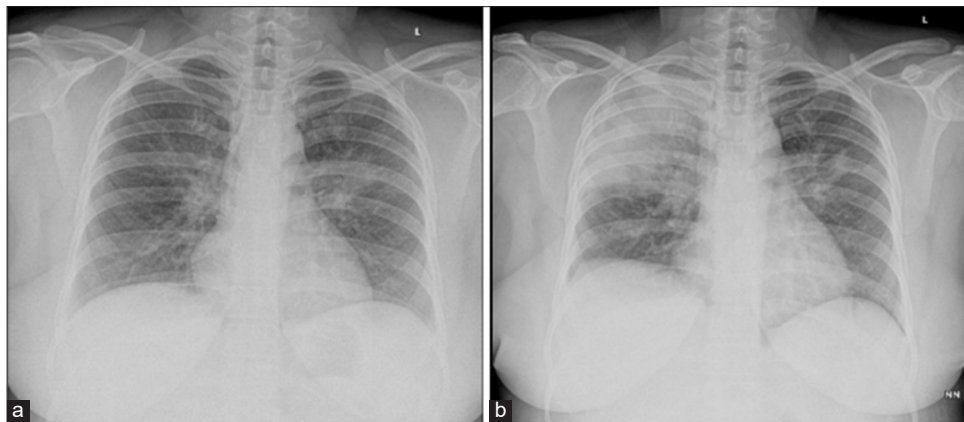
Normal chest radiograph (postero-anterior view) (a). Chest radiograph (postero-anterior view) of the same patient showing right Upper zone consolidation
